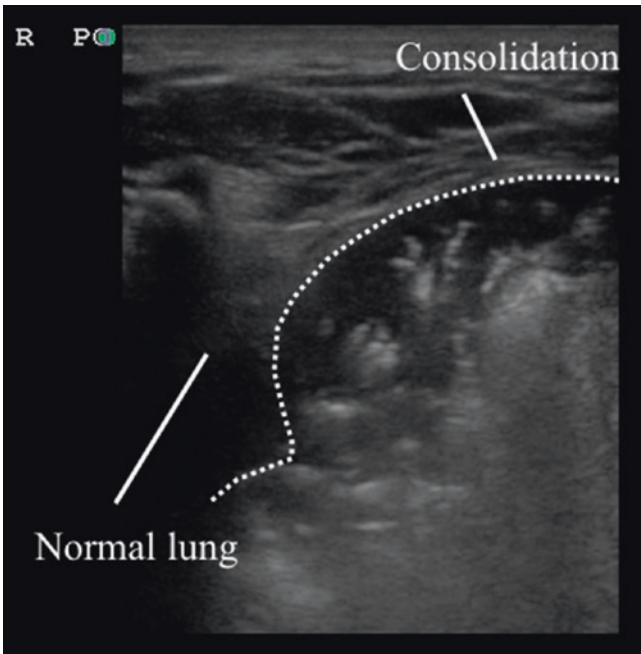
Lung consolidation with sonographic air bronchograms: transverse view
